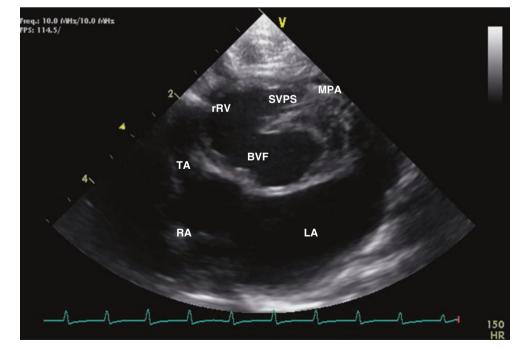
Echocardiography documenting a tricuspid atresia; the ventriculoarterial concordance is not seen in this view. RA right atrium, LA left atrium, MV mitral valve, TA tricuspid atresia, LV left ventricle, rRV rudimentary right ventricle, BVF bulbo-ventricular foramen
